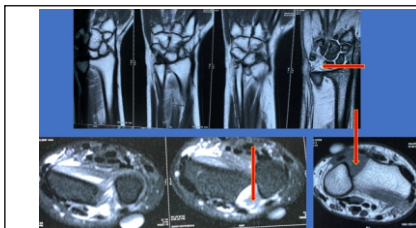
MRI- Palmar dislocation of DRUJ and dorsal near complete TFCC ligament tear.
